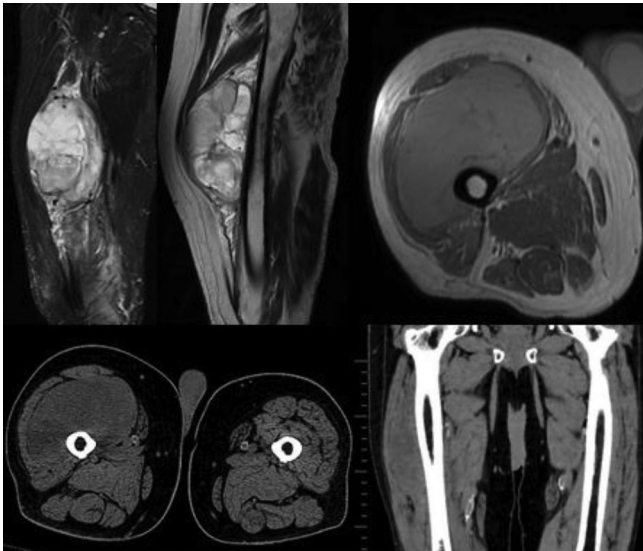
65 year old male with history of right thigh swelling, CT and MR revealed Malignant fibrous histiocyoma⁵
